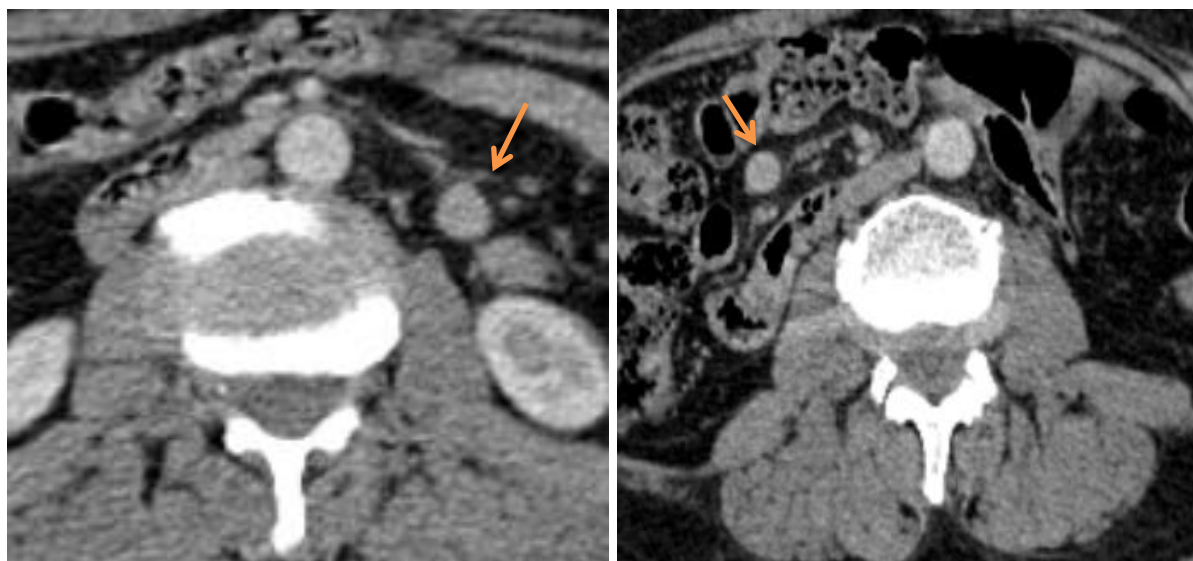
Serial CT demonstrating positional change of the wandering accessory spleen. Axial contrast-enhanced CT images obtained on (A) August 28, 2024, showing the lesion in the left para-aortic region adjacent to the left kidney (arrow), and (B) May 28, 2025, showing the same lesion in the celiac-mesenteric region (arrow). Despite its relatively stable size, the lesion demonstrates a marked change in location between the two examinations.
